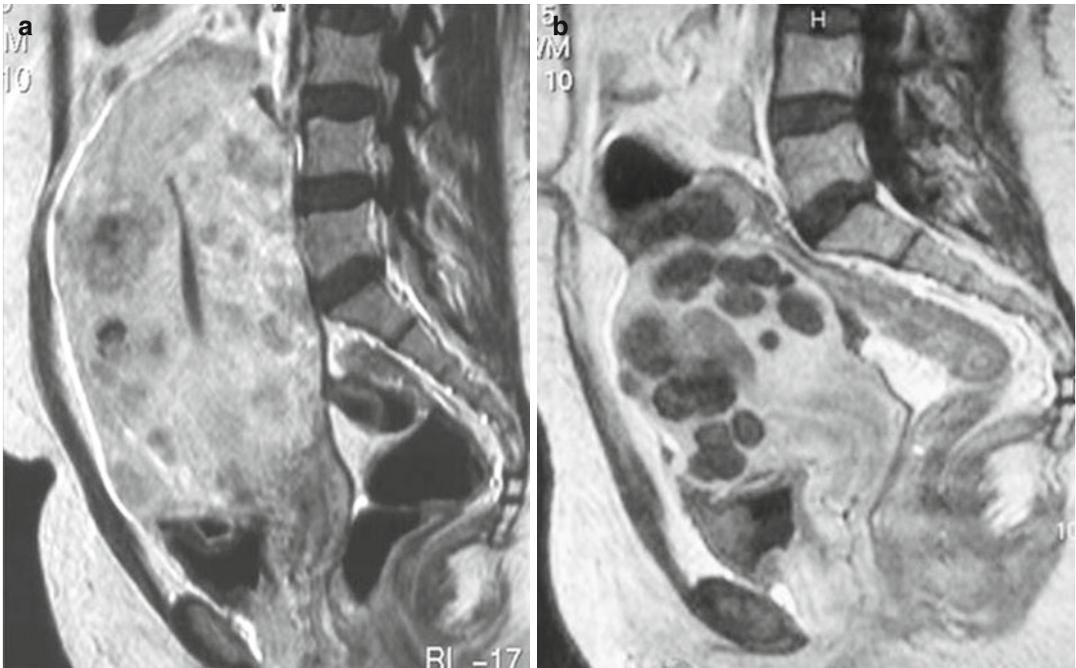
(a) Sagittal MRI demonstrating uterus with fibroids prior to UAE. (b) MRI after UAE will follow later. Sagittal MRI demonstrating same uterus with fibroids from figure a 6 months after UAE
